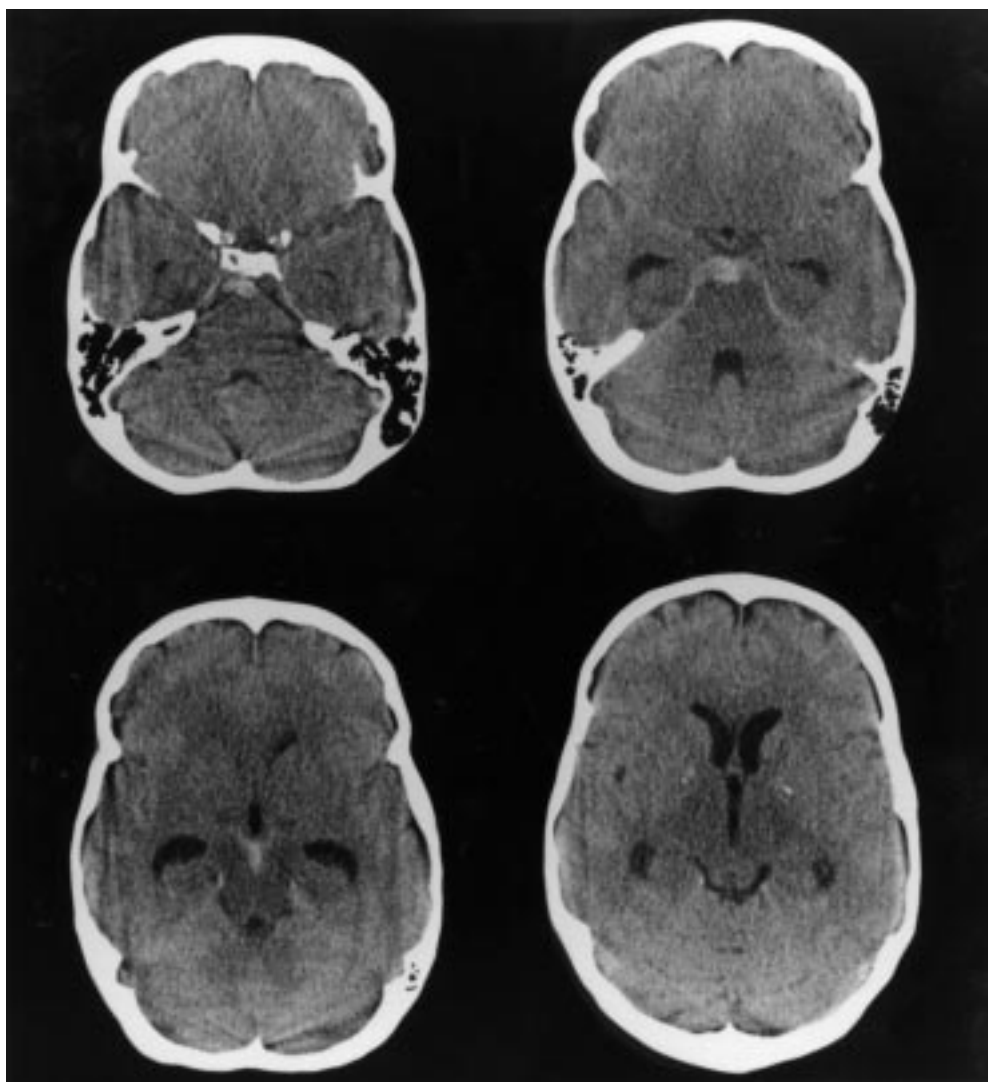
CT of a 54 year old patient with a perimesencephalic haemorrhage, performed within 24 hours after the ictus. This patient reported amnesia for the first 48 hours after the haemorrhage. The extravasated blood is accumulated in the cisterns around the midbrain (upper row right). The temporal horns are large (bottom row left), without enlargement of the frontal horns (bottom row right).
